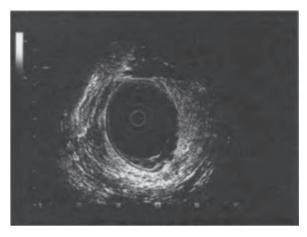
Transrectal ultrasound appearance of a rectal tumour. This is a T2 tumour showing breaching of the muscularis propria.
